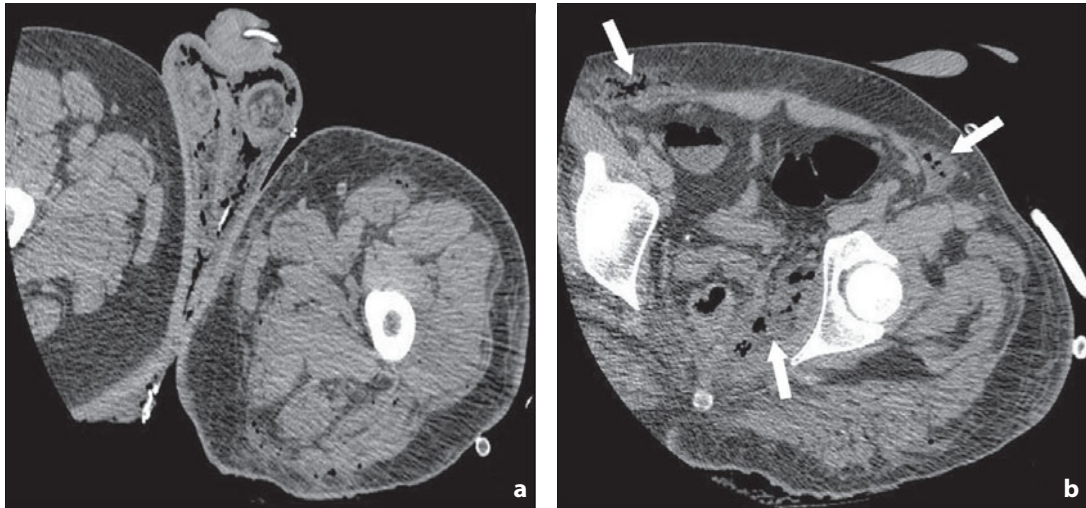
Fournier gangrene. CT scan of the pelvic and perineal region. a The presence of gas within the scrotum can be readily identified. b Image shows a collection of air bubbles in the region of the left obturator and the presence of gas in the inguinal region bilaterally (arrows)
